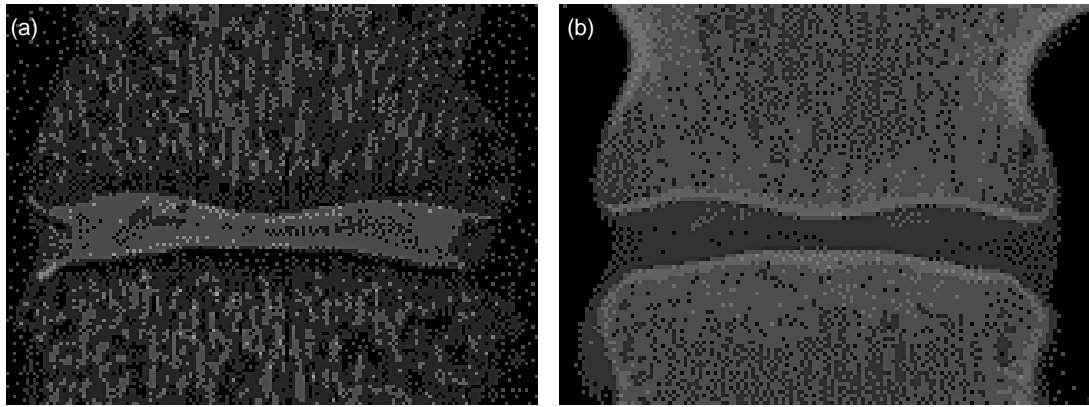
T2 weighted spin echo MR images and dissection photographs for S1 (a, b) and S2 (c, d) used for degeneration grading. S1 was graded as level II for both MR and dissection analyses. The blood shown in the centre of the disc was believed to be a result of disruption or contamination during dissection. S2 was graded as level III from MR and level I from dissection.
